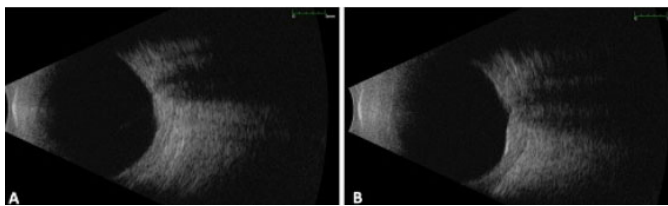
Sonography of the (A) OD and (B) OS showing attached retina and irritation free vitreous.
